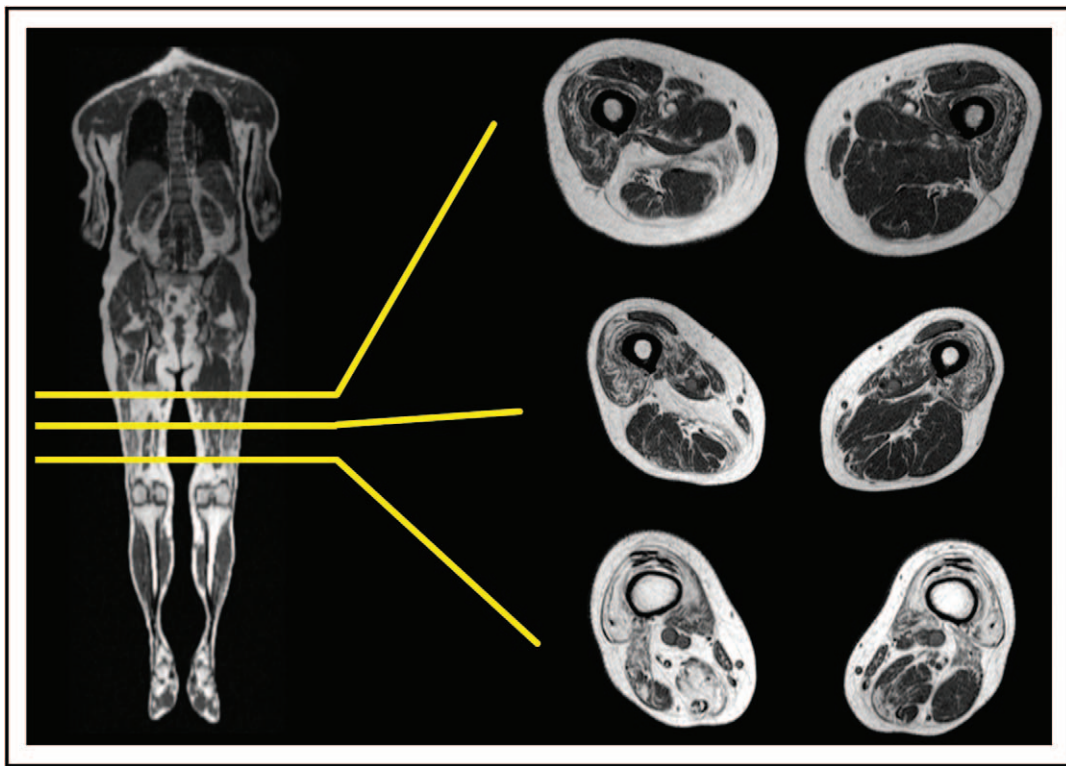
Sample images from whole body T1-weighted MRI of muscle with three axial sections through the thigh (yellow line indicates level) in a patient with inclusion body myositis. Typical fatty replacement of muscle, predominantly of the anterior musculature is evident, with a gradient of increasing severity from proximal to distal musculature.
